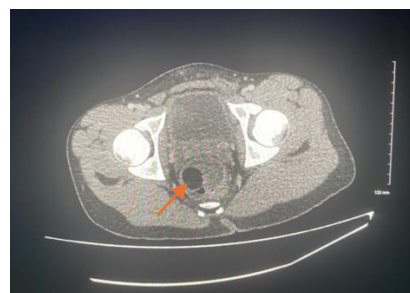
CT findings, showing the sigmoid lipoma as the lead point for the rectal-sigmoid intussusception.
